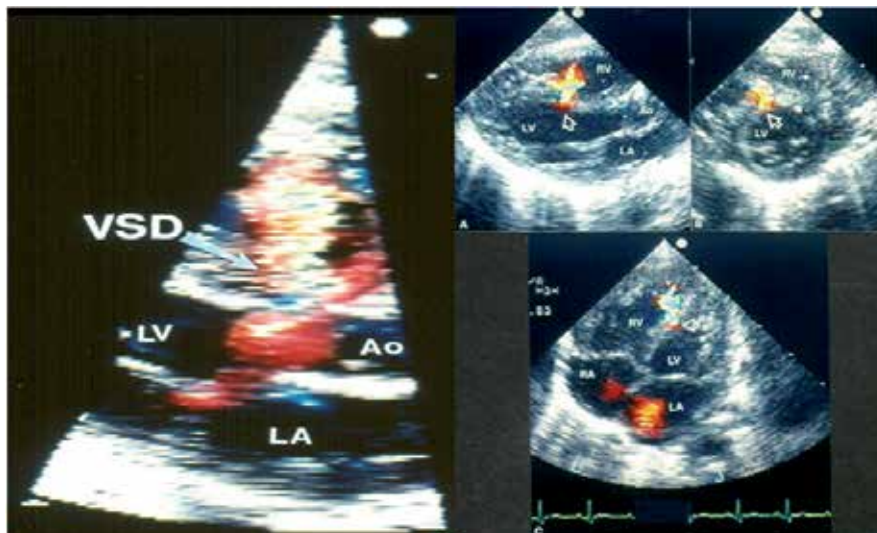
Two dimensional echocardiographic views of the ventricular septum in long axis with color flow imaging (left panel) demonstrating a perimembranous ventricular septal defect (VSD) and of the ventricular septum (arrows) in multiple views (Right panel A, B and C) with left-to-right shunt. Ao, Aorta; LA, left atrium; LV, Left ventricle; RA, right atrium; RV, Right ventricle
